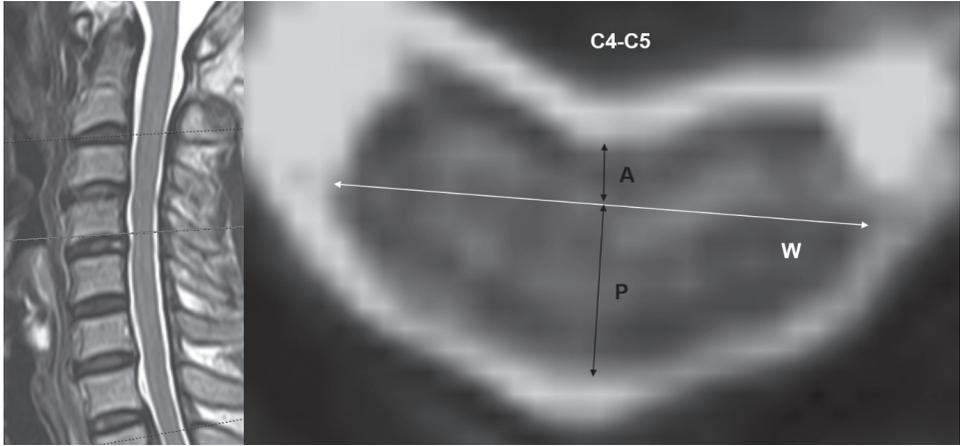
Cervical MR images of 49 year-old male patient with cervical spondylotic myelopathy. He complained severe hand clumsiness and whole body numbness. At C4-C5 level, measured values were 1.27 mm(A), 3.53mm(P) and 11.6mm(W). Anterior length(A)/Width(W) is 0.11 and anteroposterior compression ratio is 0.41. The patient’s JOA-total score was 13 (I-0, II-4, III-6 and IV-3). The patient showed more than 0.4 of anteroposterior compression ratio, but had severe neurologic deficit, especially in upper extremities.
